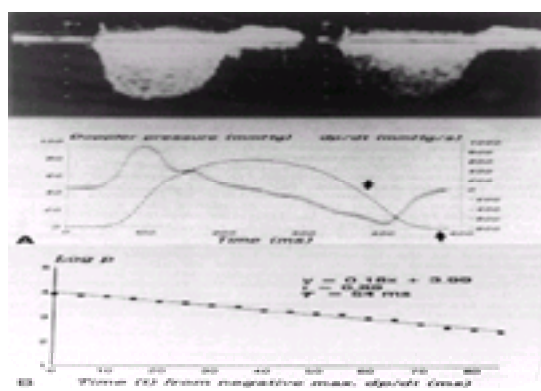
Doppler technique for measuring left ventricular (LV) rate of pressure fall, dP/dt , and the time constant of LV relaxation (T , using Doppler mitral regurgitant velocity spectrum (A, top), LV-left atrial pressure gradient and its first derivative (A, bottom), and linear plot of log LV-estimated pressure (p) versus time (B), with $T = 1/\text{slope}$). (From C Chen et al. Doppler derived dP/dt and T in mitral regurgitation. *J Am Coll Cardio*. 1994;23:970, with permission.)
